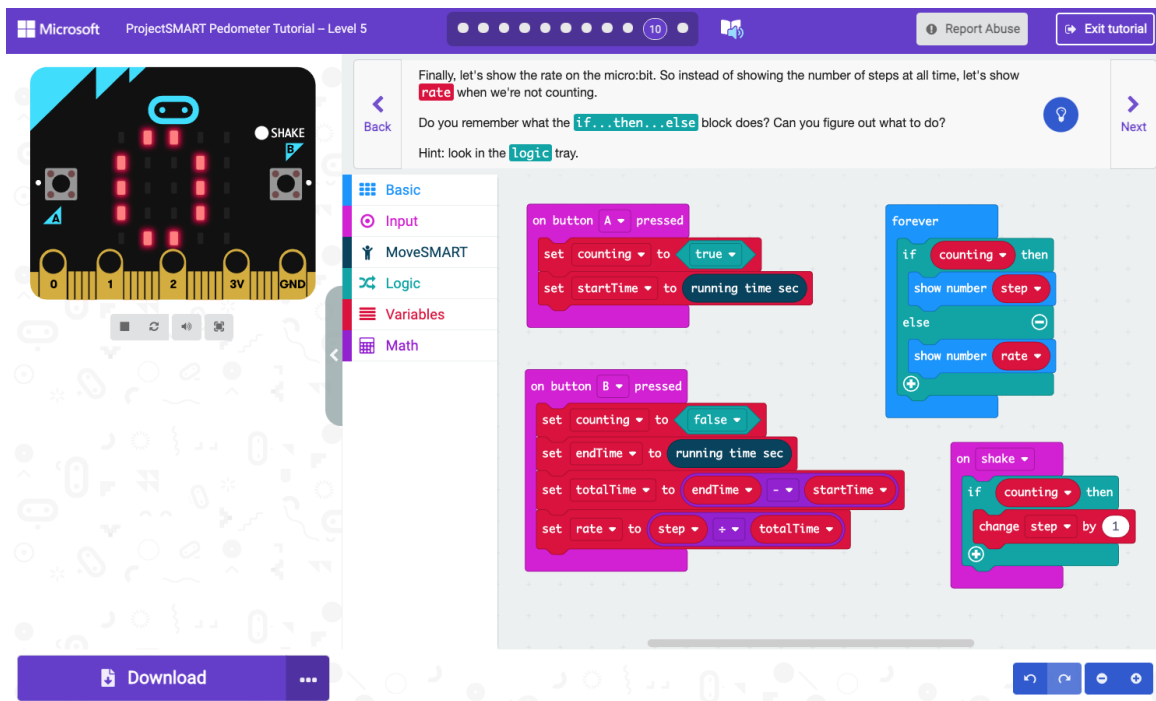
The fifth CS/CT learning activity in Project moveSMART.
